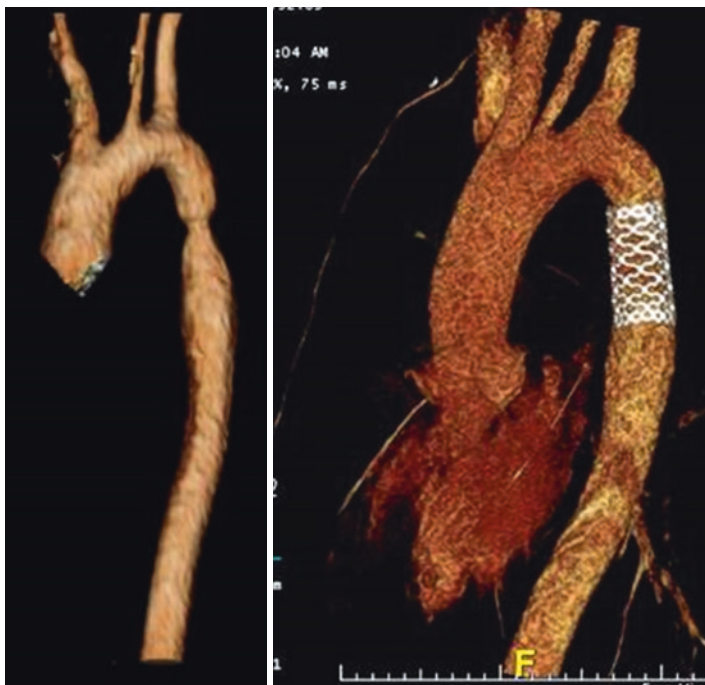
(Left) 3D-reconstructed CT angiography showing post-ductal coarctation in an adult patient who presented with exertional headaches and HTN. (Right) CTA showing the coarctation following percutaneous stenting
